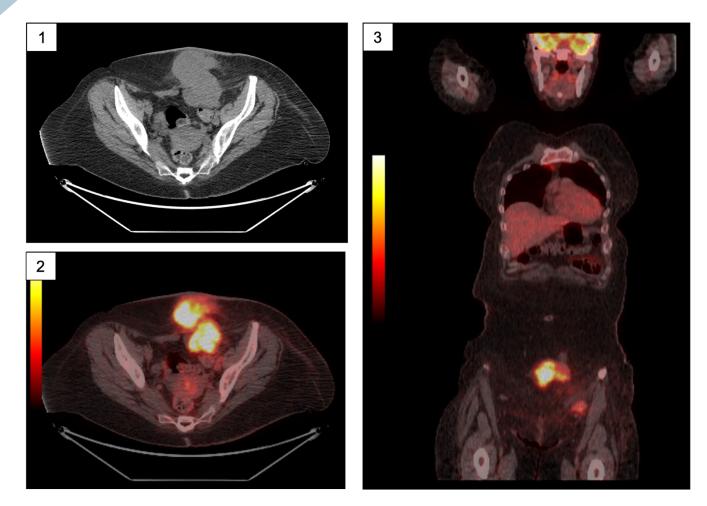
CT imaging revealing complex soft tissue mass in the left ventral abdominal wall.
